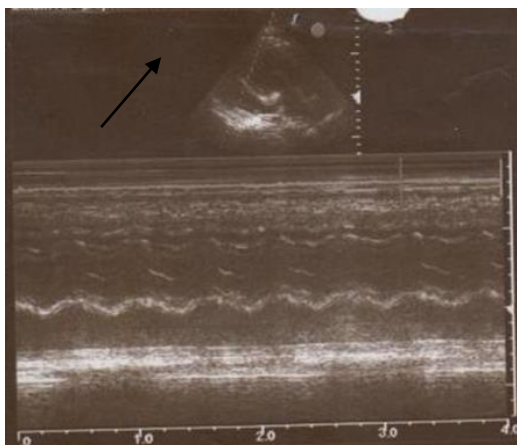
Shows transthoracic echocardiography in four chamber view shows effusion
